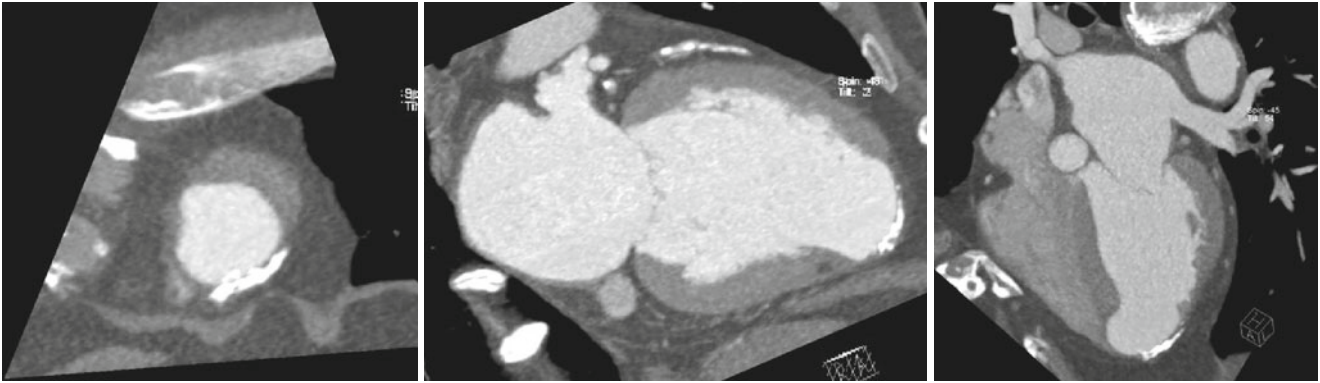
CT of patient with linear myocardial calcification. Cardiac CT (short axis, 2-chamber, 4-chamber) shows curvilinear calcification with wall thinning at LV apex and apical inferior wall
